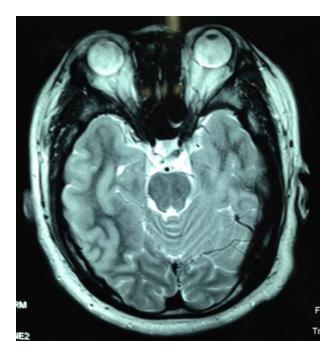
Linear flow void (arrows) suggestive of developmental venous anomaly in the left temporal lobe on T2-weighted image on MRI
